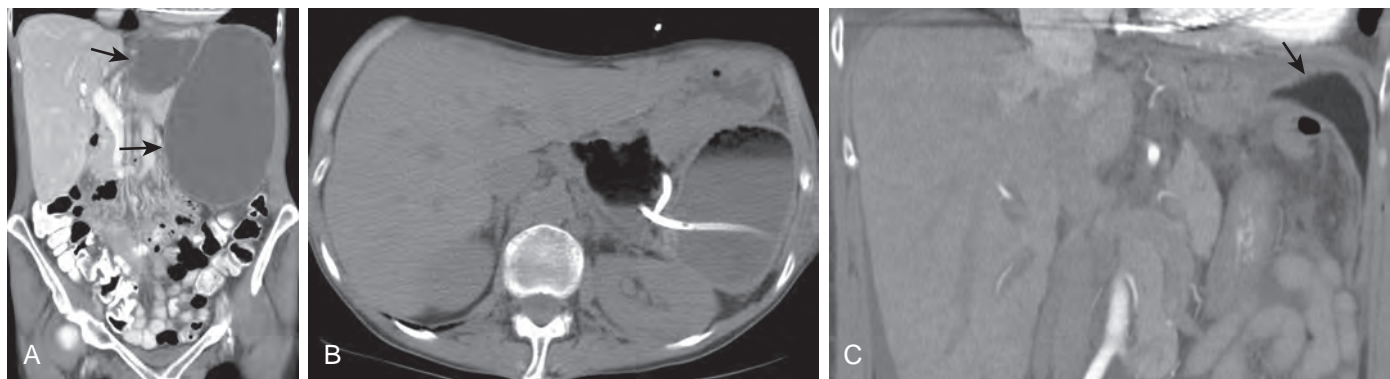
Alcohol ablation of splenic cyst. A. Contrast enhanced CT shows a large bilobed cyst (arrows) in the spleen that was symptomatic because of the mass effect. B. Axial CT shows a drainage catheter placed across the two cysts. The nondependent low-density fluid in the cysts represents the 95% alcohol injected into the cysts for the ablation procedure. C. Postablation CT scan shows marked reduction in the size of the cyst (arrow).
